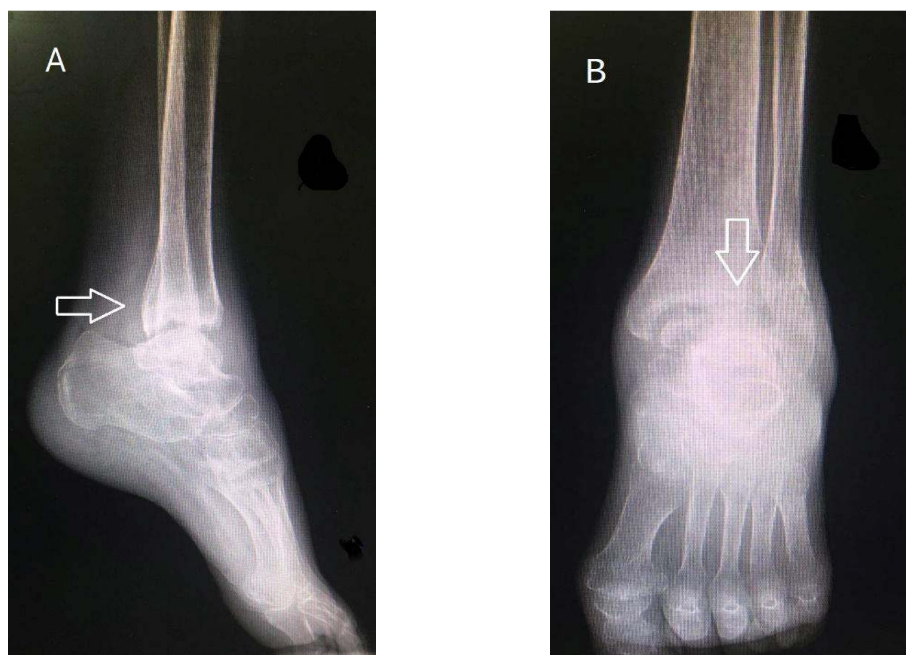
Sclerosis of the distal of tibia and decrease articular space in tibiotalar joint. (A, B) X-Ray of left foot and ankle
